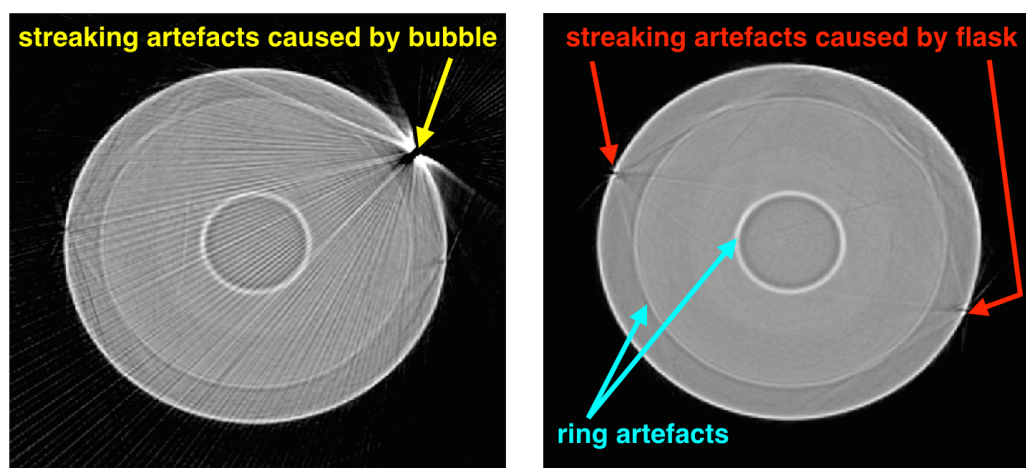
Examples of streaking artefacts and ring artefacts in optical CT. On the left, a 1 mm diameter air bubble on the surface of the flask causes widespread streaking artefacts due to refraction errors. On the right, streaking artefacts caused by seams of the flask and ring artefacts caused by corrupted detector elements are more clearly visible.
